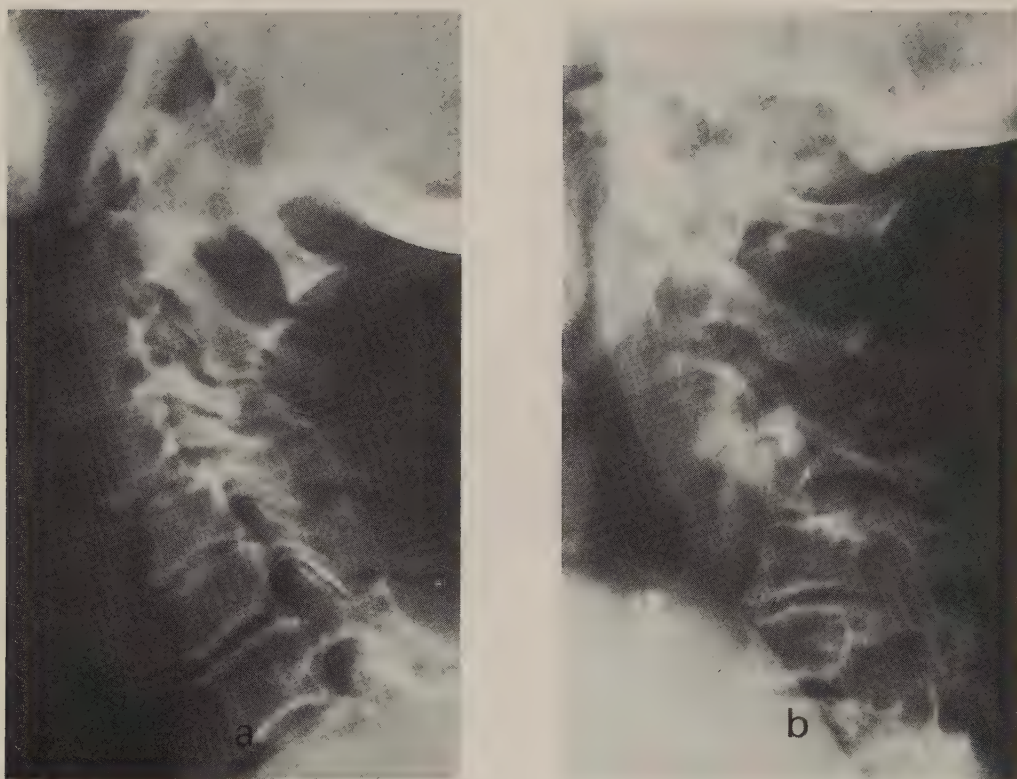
Women born 1906. a) Lateral radiograph from 1976 with subluxations at C3 - C5. b) Lateral radiograph a year later showing deterioration. At the C4 - C5 level the subluxation is 8 mm and the sagittal diameter 12.5 mm. The patient had no neurological symptoms. There are only minor changes at the level of C1 - C2.
